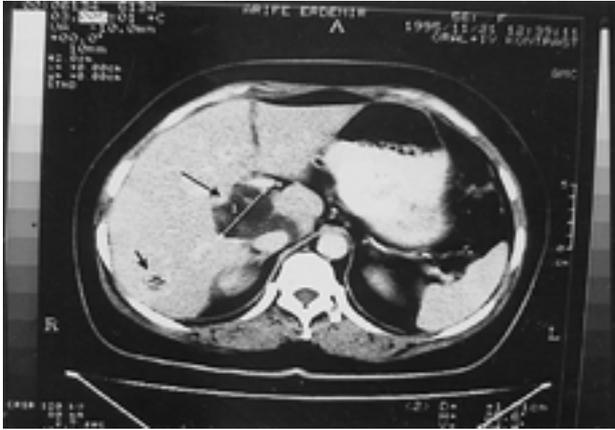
The initial CT of the patient (November 1995) with IV contrast, showing lesions in the right and caudate lobes of the liver.
